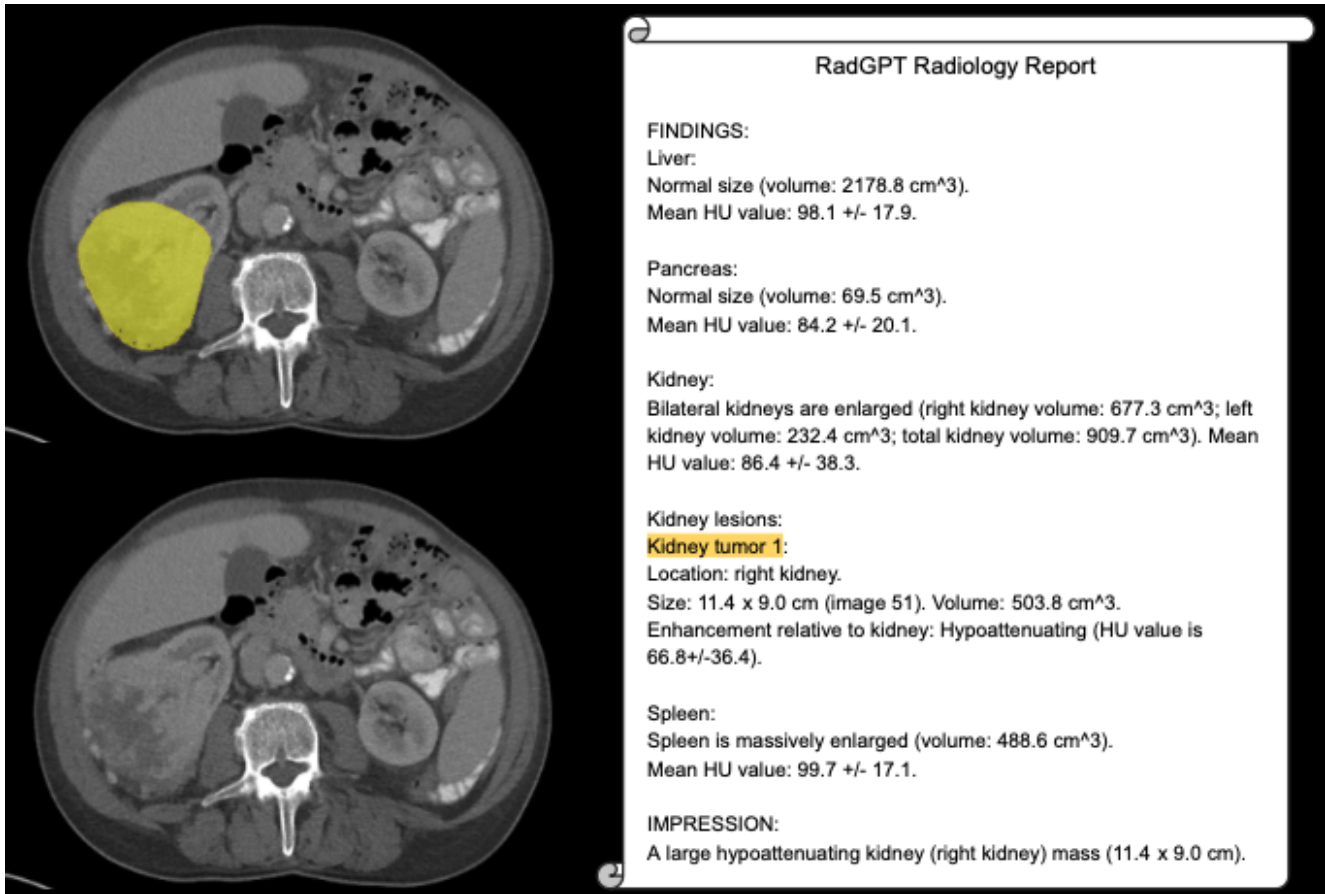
CT scan showing a large kidney tumor (yellow) and our report.
